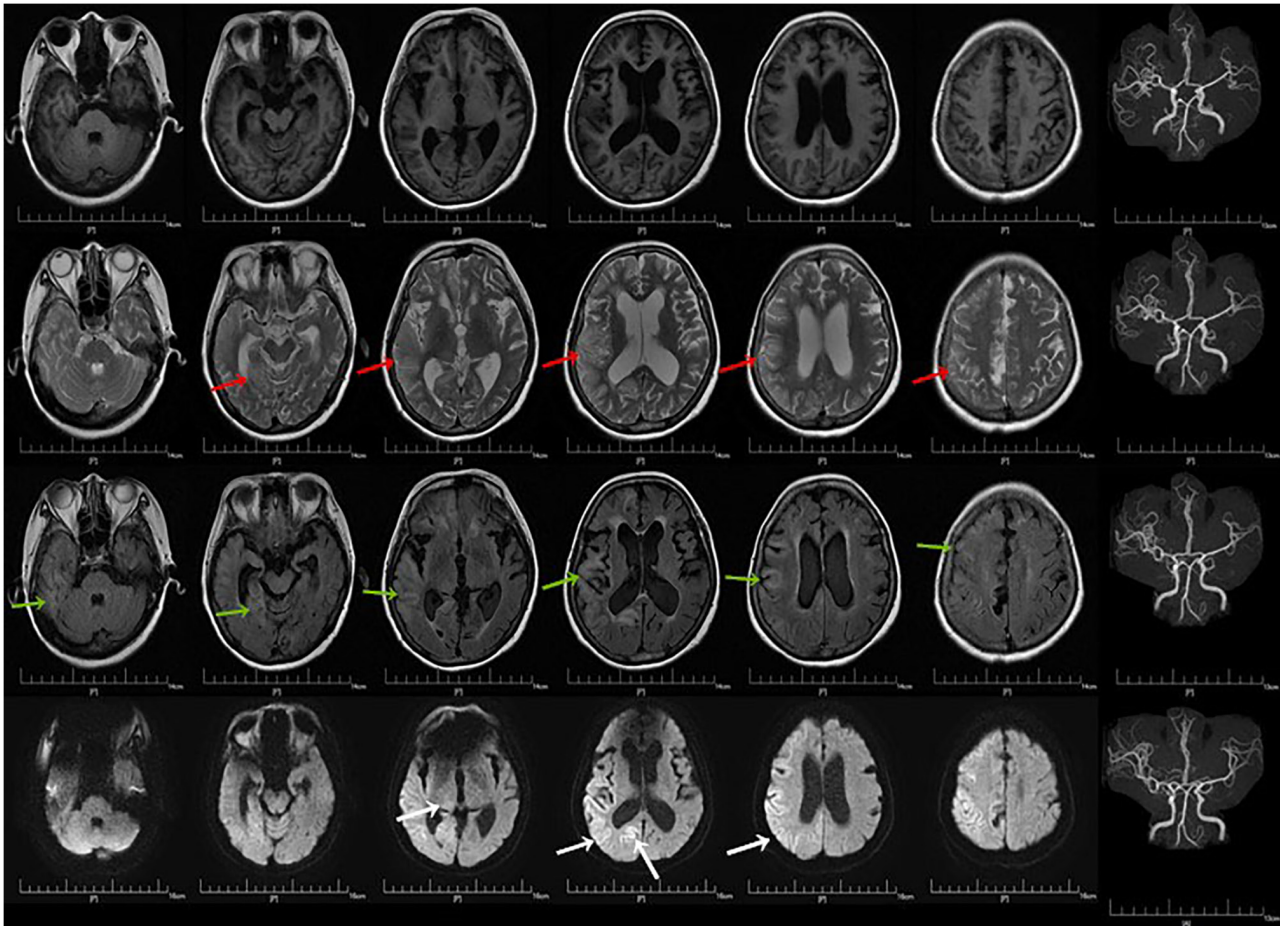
Brain magnetic resonance imaging performed in August 2025, at 1 day post-admission. Fluid-attenuated inversion recovery sequence (green arrow) and T2-weighted imaging (red arrow) demonstrated hyperintensity in the right cerebral cortex and subcortical white matter involving the frontal, parietal, temporal and occipital lobes, as well as the insula and thalamus. DWI (white arrow) demonstrated acute changes in the fronto-temporo-parietal cortex. The DWI hyperintensity in the right thalamus shown in Fig. 2 had diminished or was no longer clearly visible on this DWI examination. DWI, diffusion-weighted imaging.
